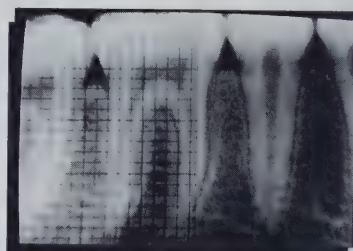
Monitor image of radiograph with 1.0 mm x 1.0 mm grid superimposed.
